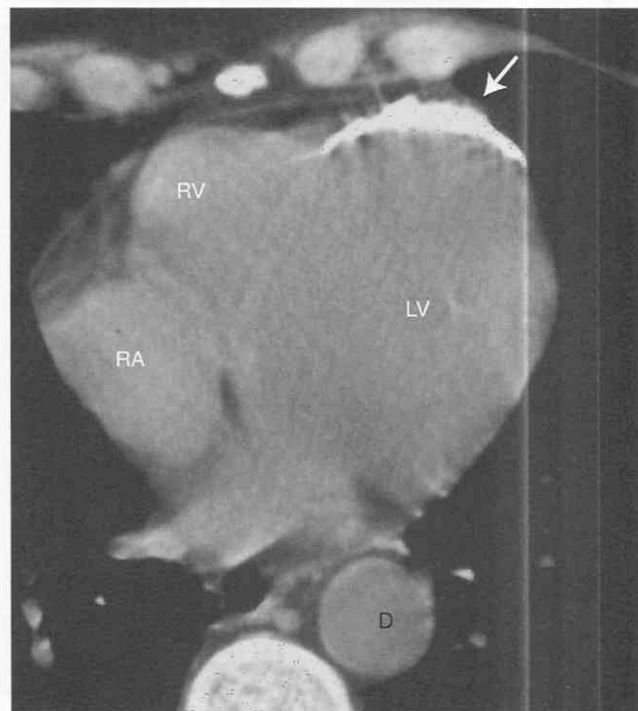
Calcified myocardial infarct. Noncontrast-enhanced CT shows dense calcification of the left ventricular apex (arrow) in this patient known to have a history of myocardial infarction. D, descending aorta; LV, left ventricle; RA, right atrium; RV, right ventricle.
